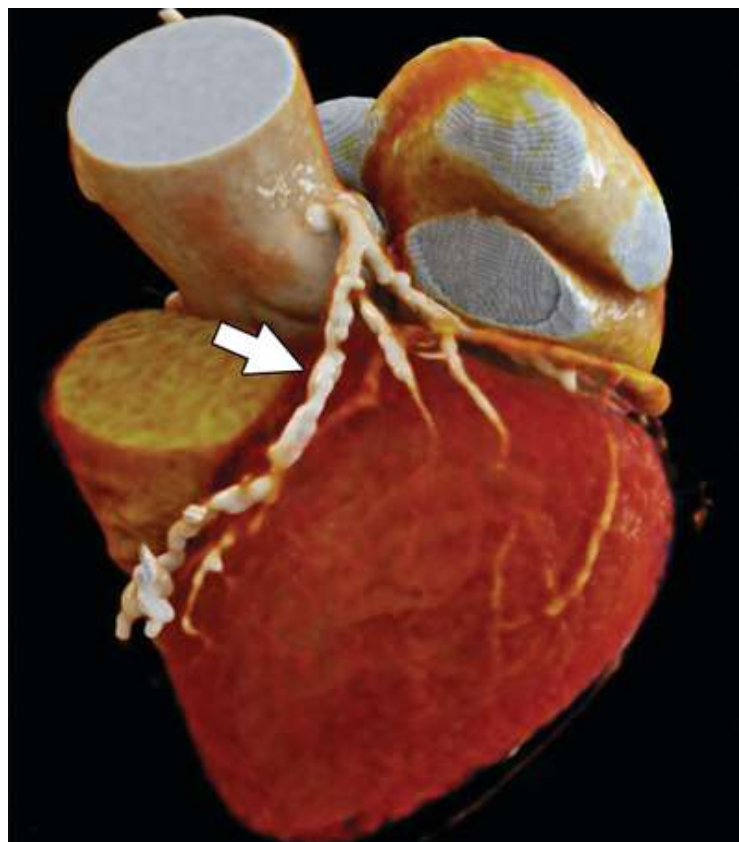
A 65-year-old woman is having her heart and coronary arteries CT-angiograph. because she has chest pain.
